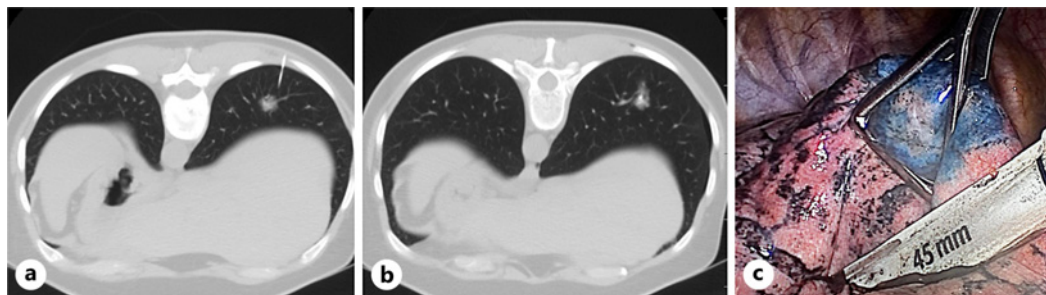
a, b Axial CT scan of preoperative marking of the nodule. a Insertion of a fine needle under CT control to the bearing. b Scan after injecting a small amount of the marking mixture near the nodule. c Videothoroscopic view of the marked part of the lung tissue before its resection.
